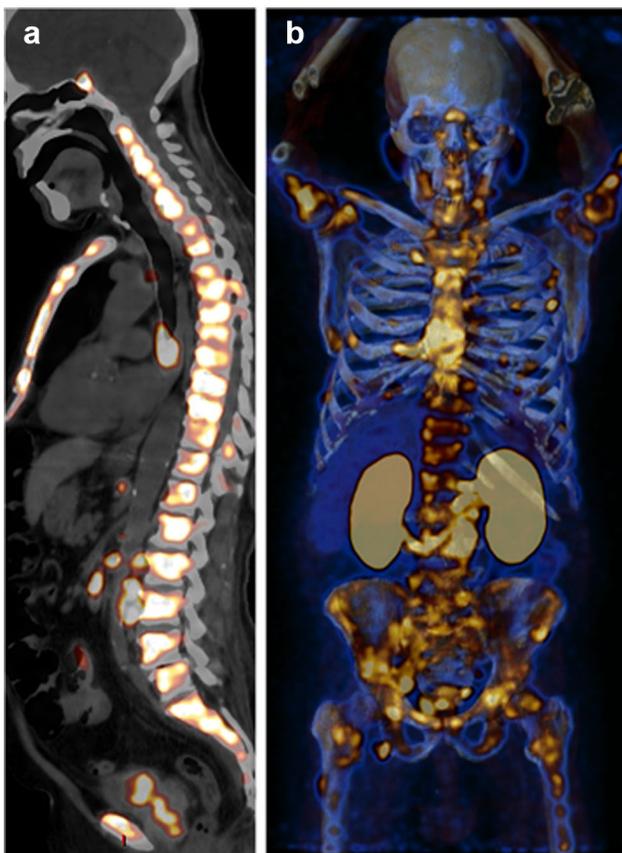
A 73-year-old man with newly diagnosed PC referred for initial staging (PSA level: 145 ng/mL; GS: 5+5). a Sagittal and b Coronal ^{68}Ga -PSMA PET/CT images showing the axial and appendicular skeletons are totally replaced by heavily infiltrating diffuse ^{68}Ga -PSMA-avid metastatic osseous lesions, the most avid one achieves SUV_{max} of 15
